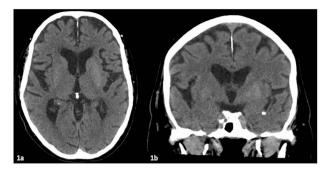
CT brain scan. (1a) Axial view and (1b) coronal view. Mild hyperdensity in both basal ganglia was present, slightly more prominent on the left.
